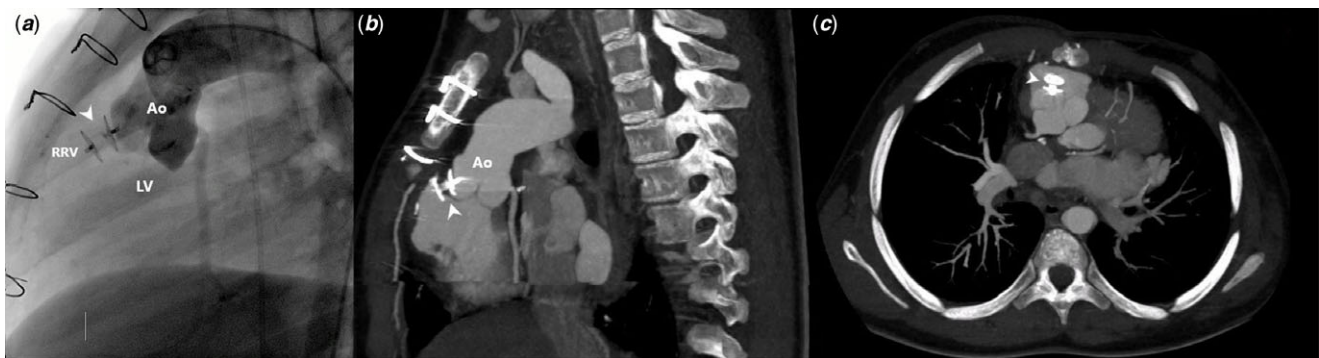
One-year follow-up control imaging with ascending aortogram (a) and multi-planar modified CT-scan reconstructions (b, c). Note device stability, complete shunt closure, and preserved aortic valve competence (white pointed arrow). Ao = aorta; LV = left ventricle; RRV = rudimentary right ventricle.
